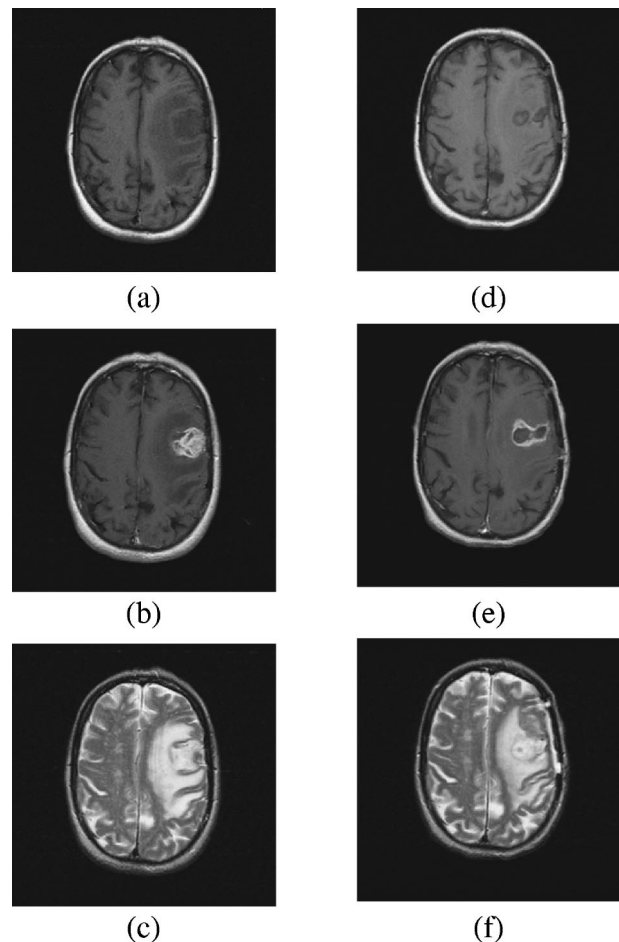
Same case as in Figure 6: comparison of pre- and post-operative images. Pre-operative image: (a) T1-weighted image (axial, TR/TE 400/16 ms, slice thickness 5 mm, FOV 220×220 mm, matrix 256×192 pixels). A large alteration of intensity is noted in the left frontal and parietal regions with compression of the sylvian fissure. Associated with hypo-intense alteration of the adjacent white matter, a compression of the left lateral ventricle and slight middle shift is seen. (b) Gd-enhanced T1w image (TR/TE 500/16 ms) shows left hemispheric abnormality with a 3 cm area of contrast enhancement. (c) T2-weighted image (TR/TE 3000/95 ms). A significant hyperintense alteration of the white matter surrounds the tumor and extends into the frontal and parietal lobes. Post-operative images 3 days after the LITT. (d) T1-weighted image (TR/TE 400/16) indicates the two laser-induced lesions. Compared to the examination done before LITT, there is a decrease in size of the residual alteration of intensity in the left fronto-shaped area of max. 1.5 cm in diameter. (e) Gd-enhanced T1 (TR/TE 500/16 ms) showed no contrast enhancement at the center of the lesion, although there is an enhancing rim around the tumor site. (f) T2w image (TR/TE 3000/95 ms) has low intensity in the center of the tumor site and high intensity in the rim. The surrounding vasogenic edema has less compression of the left lateral ventricle.
